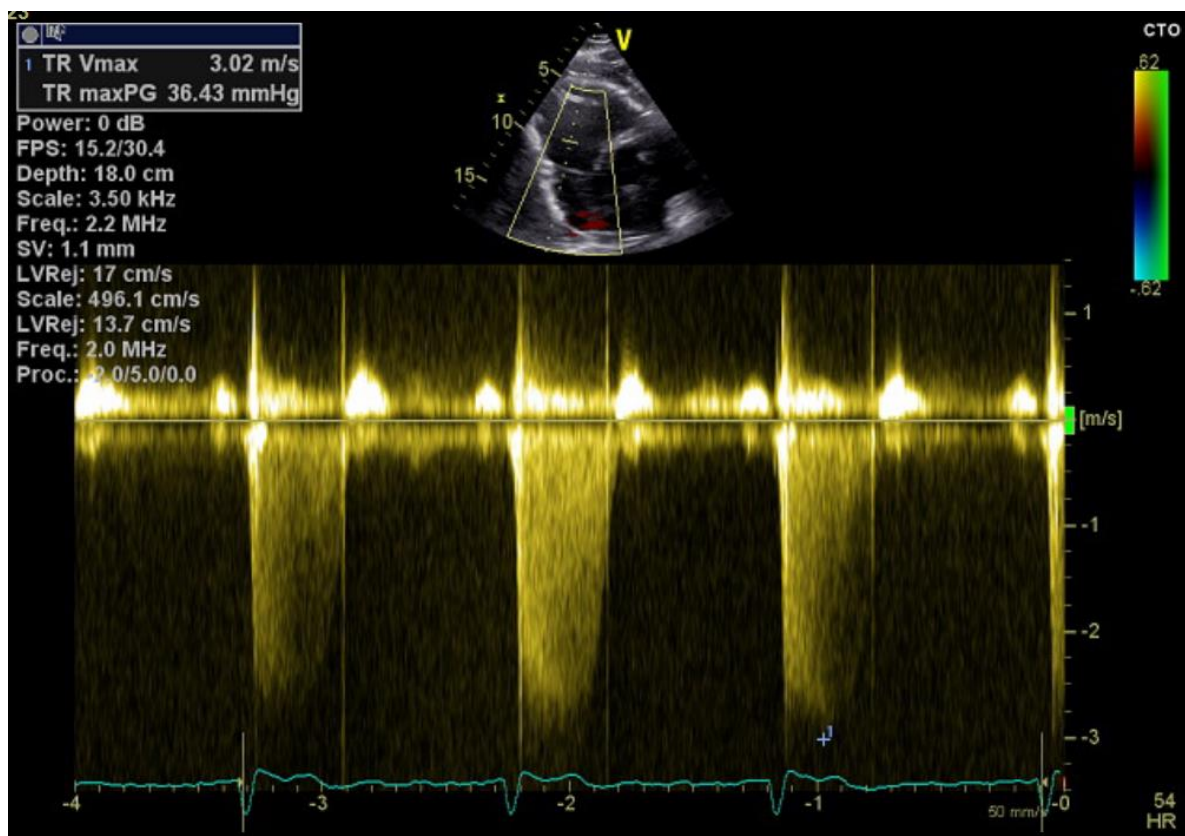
Maximal tricuspid regurgitation velocity measurement by Doppler echocardiography. This patient had a measured TR of 3 m/s which corresponded to a TRPG of 36 mmHg.
